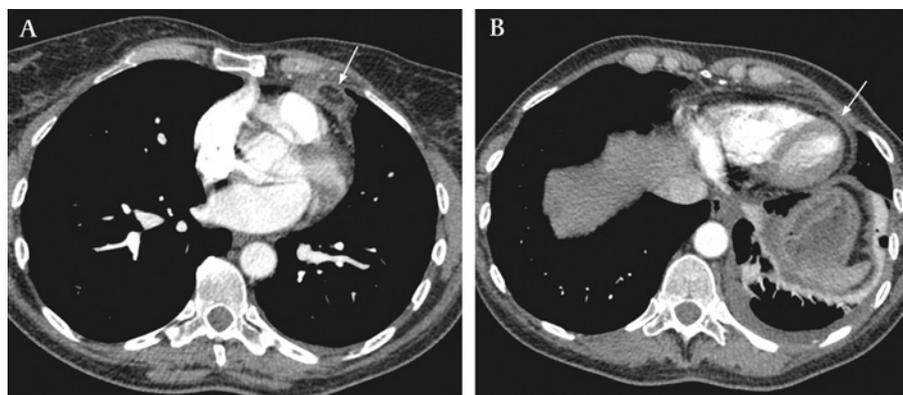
Contrast-enhanced axial CT images. Pericardial thickening (arrow) and pleural effusion. *See page 188.*
